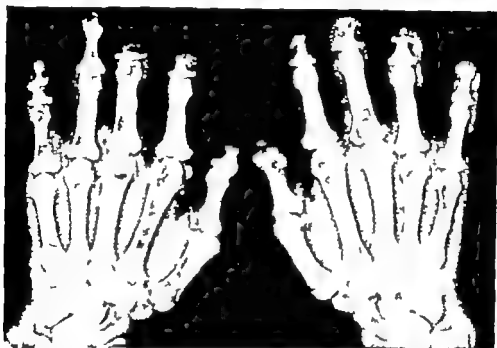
Roentgenogram showing destruction of terminal phalanges in a case of leprosy
